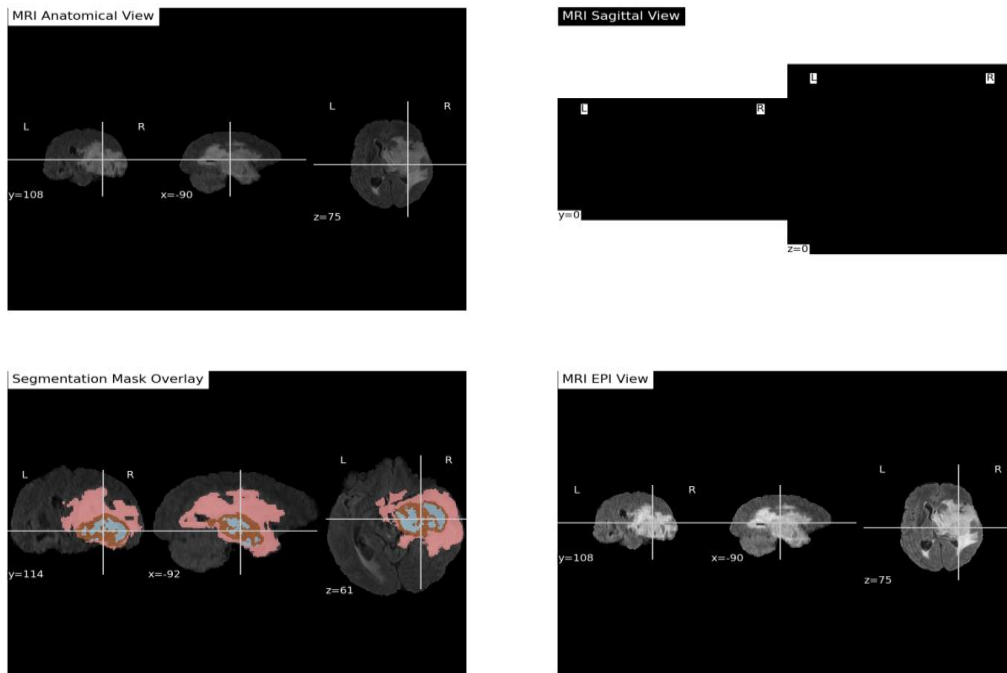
Different views of MRI data with segmentation overlay.
